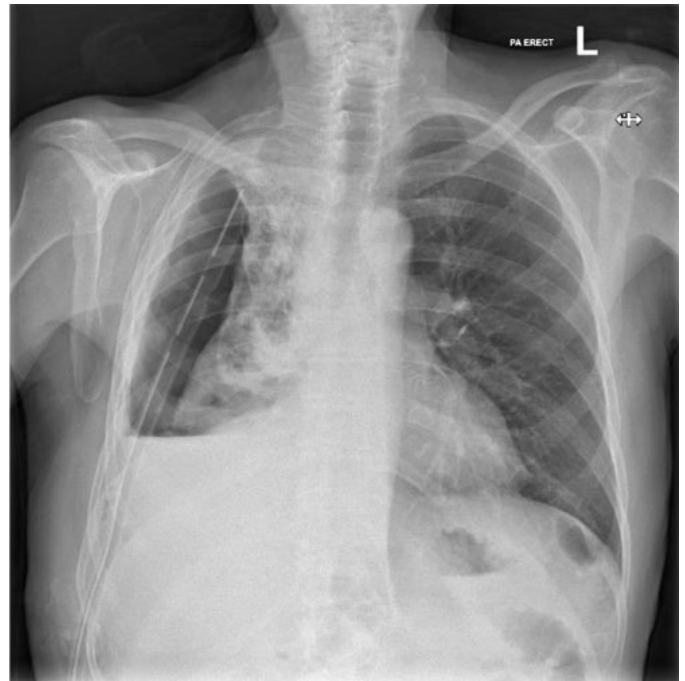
Chest radiograph showing non expandable lung—a large bore drain is clearly seen with the lung collapsed down and air present in the hemi-thorax.
